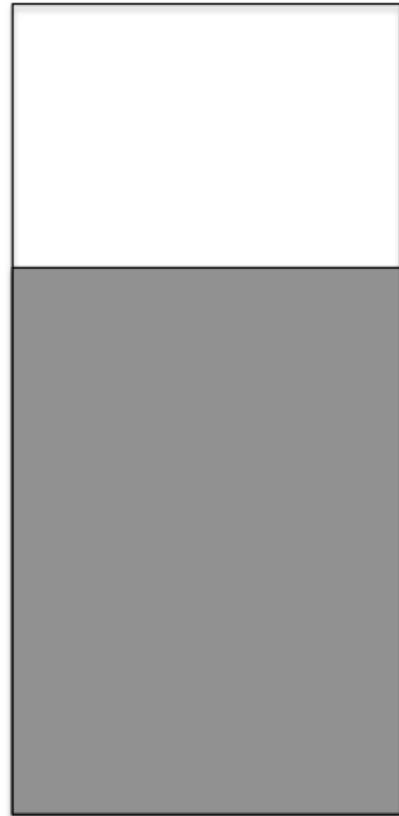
Visual representation of arousal and preference rating scale projected inside the MRI scanner.
